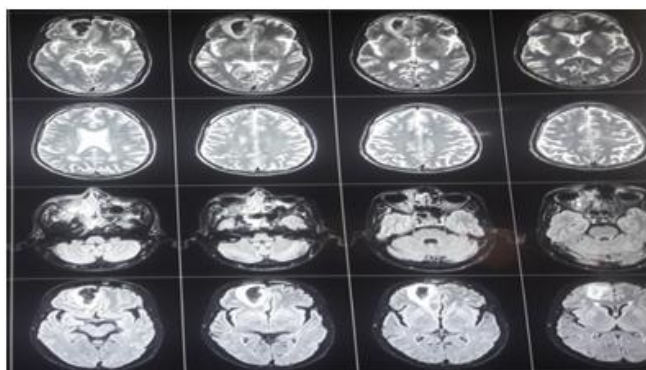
MRI BRAIN WITH ORBIT
